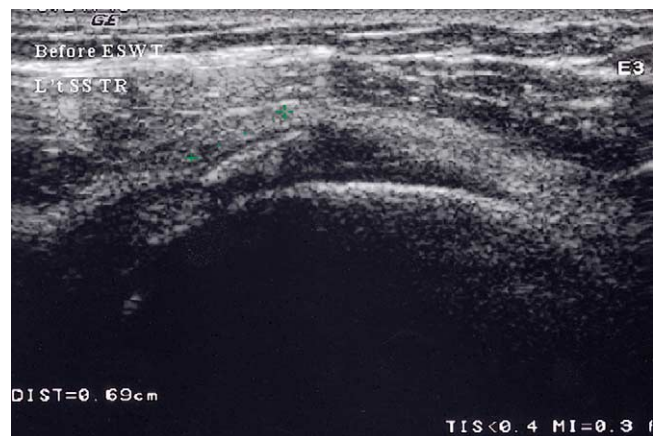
Transverse high-resolution ultrasonographic image of the left supraspinatus tendon showing arc-type calcific plaque before ESWT.
